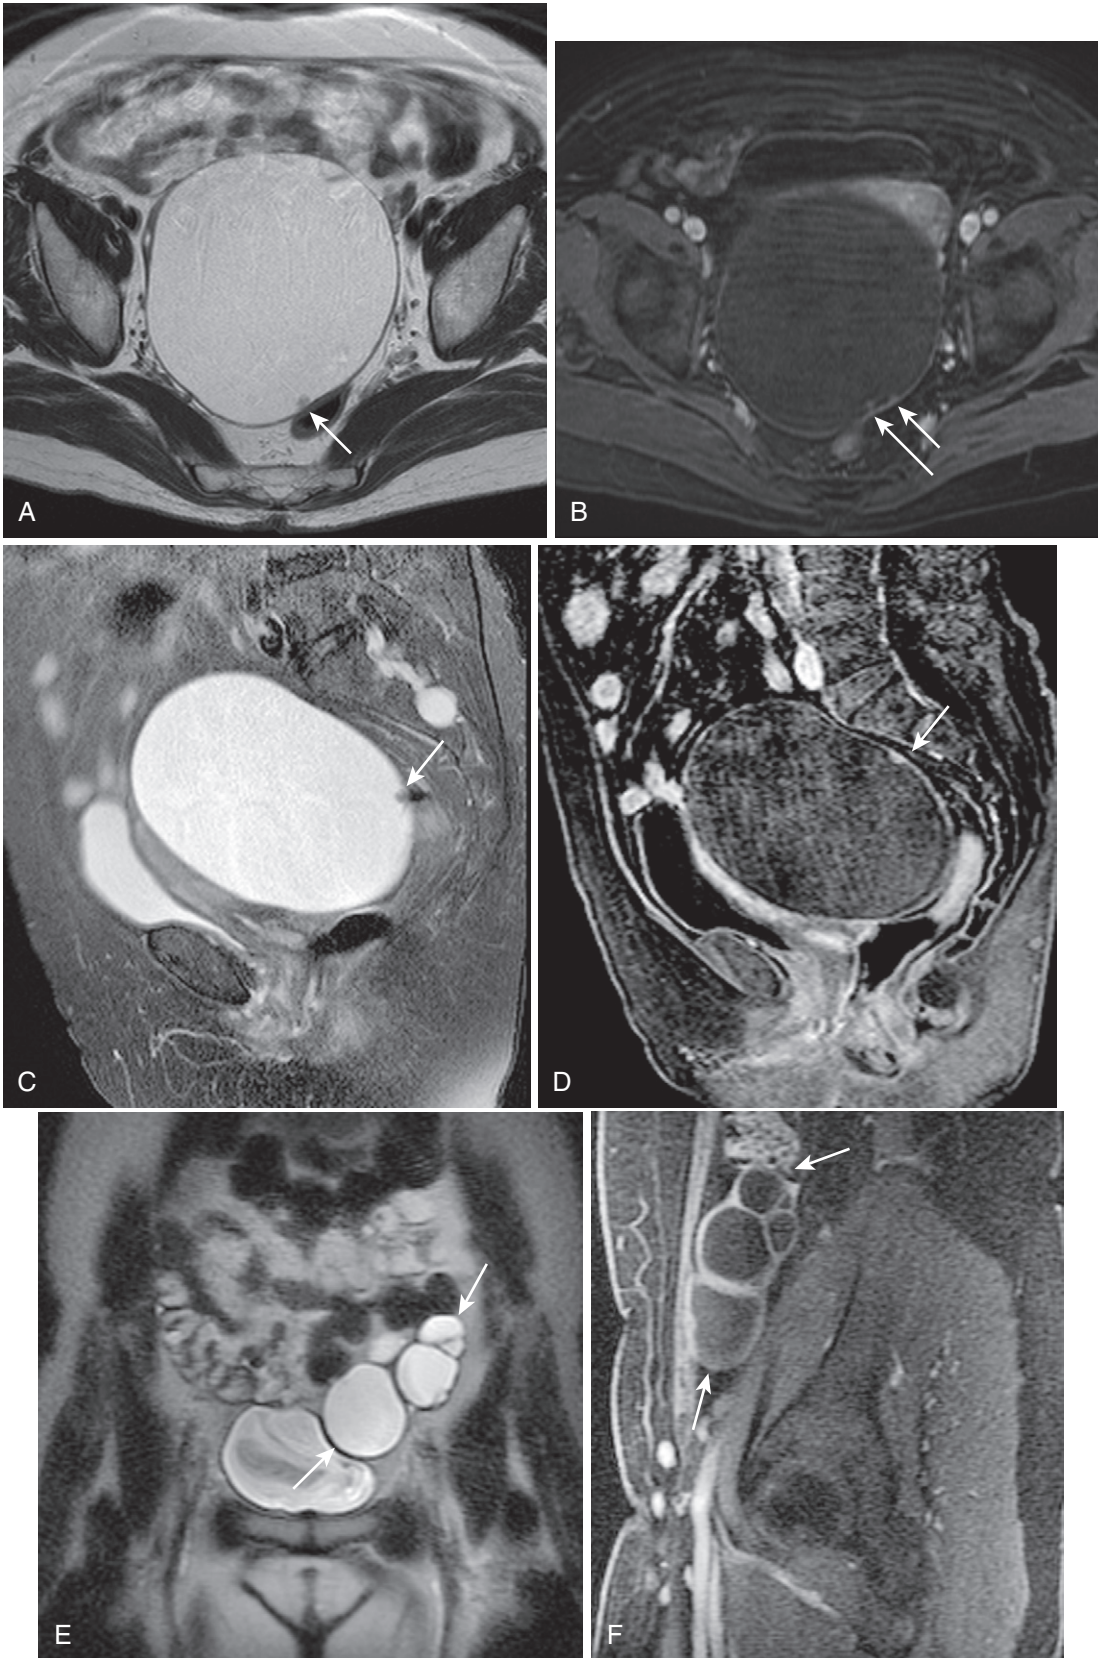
Serous cystadenoma. Axial T2-weighted (A) and enhanced (B) and sagittal T2-weighted (C) and enhanced (D) images. A large unilocular cystic lesion is virtually indistinguishable from a simple (functional) cyst except for the relatively large size and few inconspicuous mural nodules (*arrows* in A, B, C, and D) underscoring the importance of closely scrutinizing these lesions, especially when large. Although more often unilocular than its mucinous counterpart, the serous cystadenoma also expresses multilocular morphology (*arrows* in E and F), as seen in a different patient (coronal T2-weighted [E] and sagittal [F] enhanced images).
